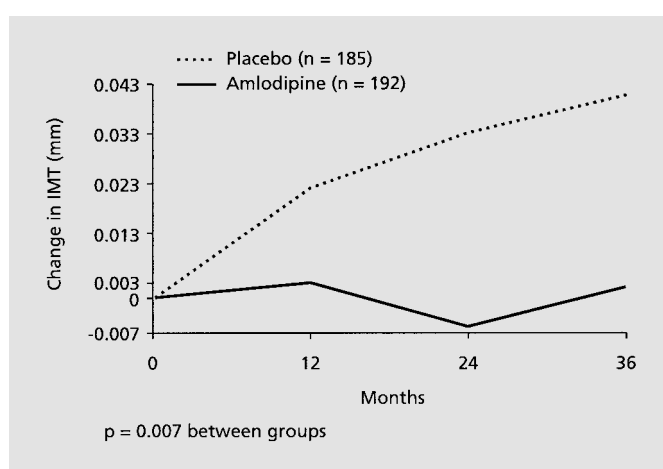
The Prospective Randomised Evaluation of the Vascular Effects of Norvasc Trial (PREVENT): the dihydropyridine-type calcium channel blocker amlodipine slows the progression of carotid atherosclerosis, as measured by B-mode ultrasound [21]. IMT = Intima-media thickness.
